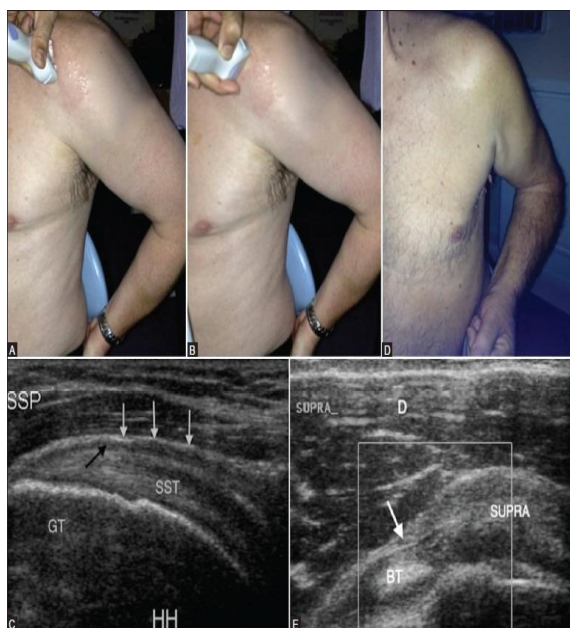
Ultrasound examination of Supraspinatus tendon
